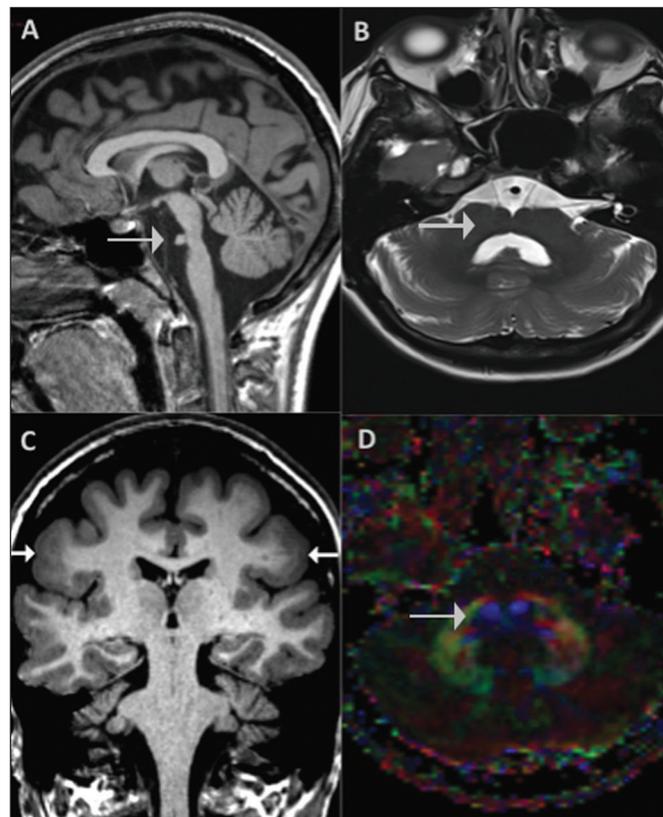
A: Sagittal T1-weighted image depicting a short pons (arrow). B: Axial T2-weighted image at the pons-medulla junction showing a ventral cleft (arrow). C: Coronal T1-weighted image showing cortical dysplasia (arrows) with a thickened cortex. D: Axial fractional anisotropy color map showing the absence of transverse pontine fibers and of the medial lemniscus (arrow).
